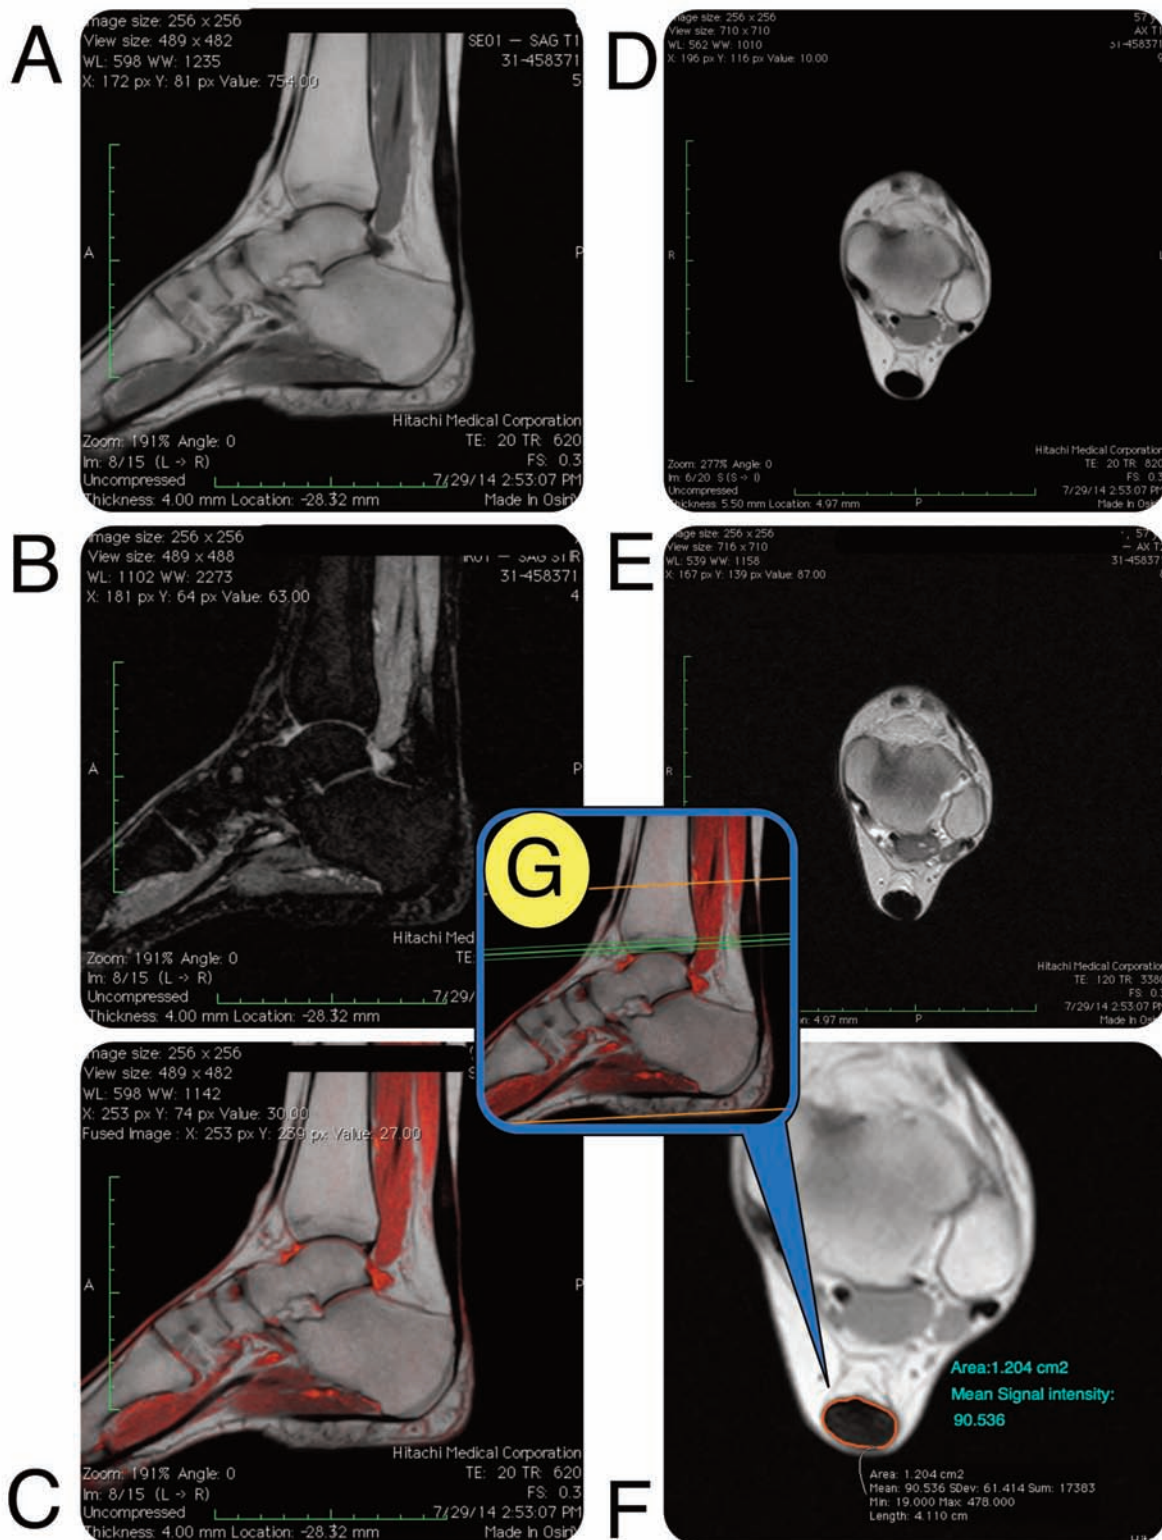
MRI of the patient's left ankle 32 weeks post-operatively, performed on a Hitachi 0.3 Tesla device. The name of the patient has been blacked out. T1 images used for calculations were both performed with a TE of 20, and a TR of 820, utilizing 5.5 mm slice thicknesses. Color fusion with OsiriX Imaging Software. *A*, Sagittal T1 left ankle. *B*, STIR Sagittal left ankle. *C*, Sagittal T1 fused with a sagittal STIR left ankle. *D*, Axial T1 left ankle. *E*, Axial T2 Fast Spin Echo left ankle. *F*, Axial T1 zoomed to better show the image measurement of signal intensity and area of involved tissue left ankle. *G*, Scout view – center green line represents the image slice in *F* taken at the most involved portion of the tendon—left ankle. Special thanks to Dr. Paul Marsh, D.O. of Monticello Diagnostic Imaging for compiling these images.
